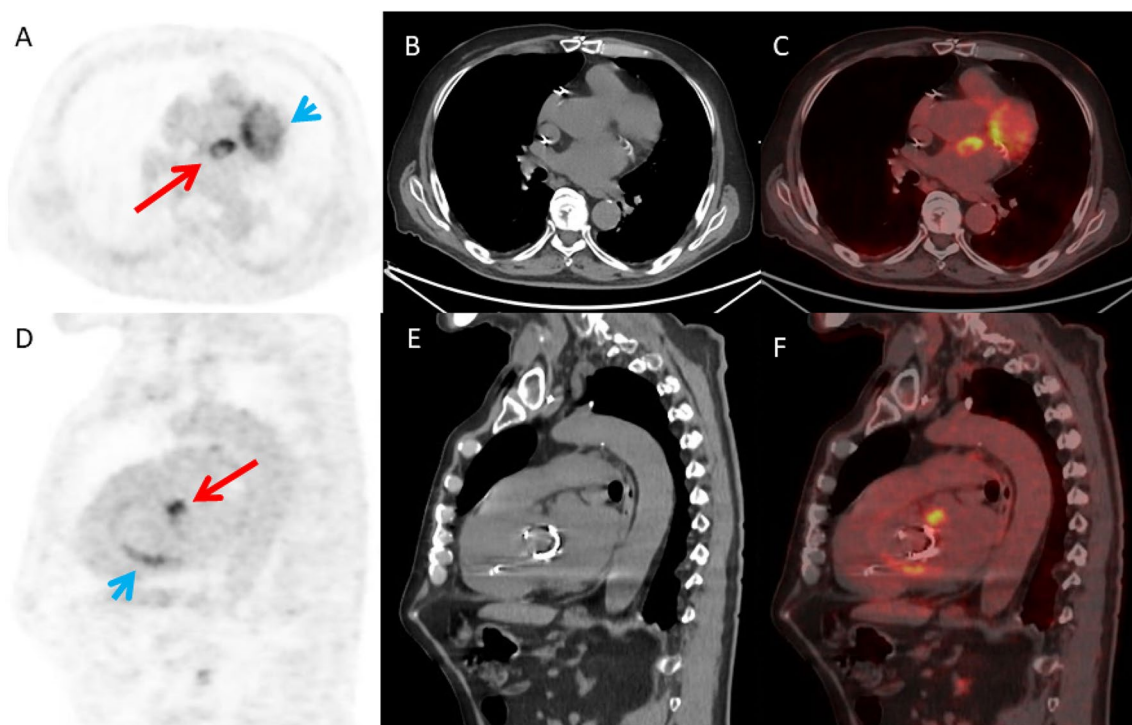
Focal FDG-uptake in an infective abscess in the root of the aorta (red arrow) in close proximity of the TAVI (transcatheter aortic valve implantation)-prosthesis. No positive blood culture. Note diffuse uptake around the TAVI-prosthesis (blue arrowhead), consistent with physiologic, reactive activity
